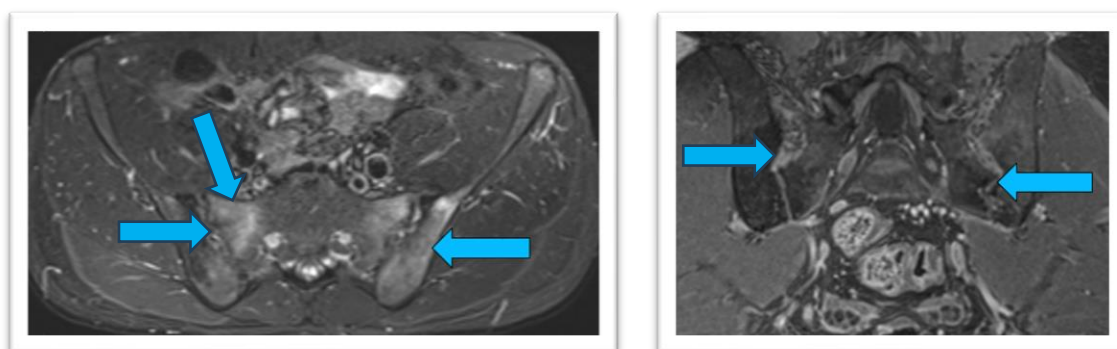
MRI signal alteration on both sacroiliac joints (arrows).*
